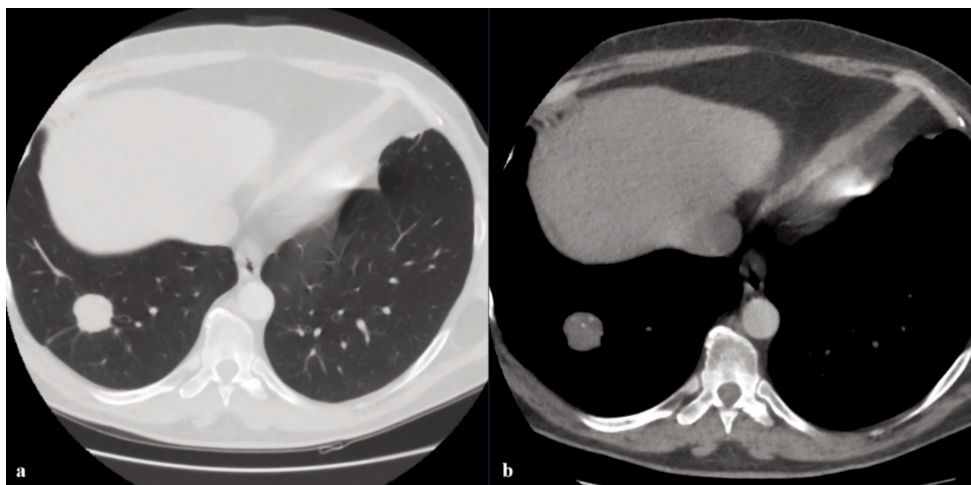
a,b) Non-contrast chest Computed Tomography (CT) shows an irregular margined mass with millimetric calcification in the lower lobe of the right lung.
